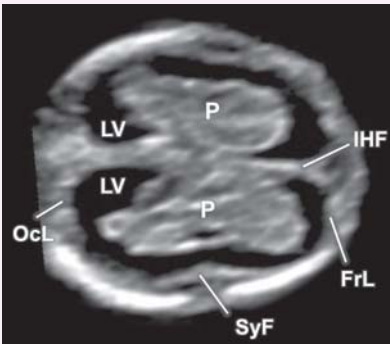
Axial view (supratheralamic section) on two-dimensional ultrasound imaging in normal 11–13-week fetus. FrL, frontal lobe cortex; IHF, interhemispheric fissure; LV, lateral ventricle; OcL, occipital lobe cortex; P, choroid plexus; SyF, future Sylvian fissure.
